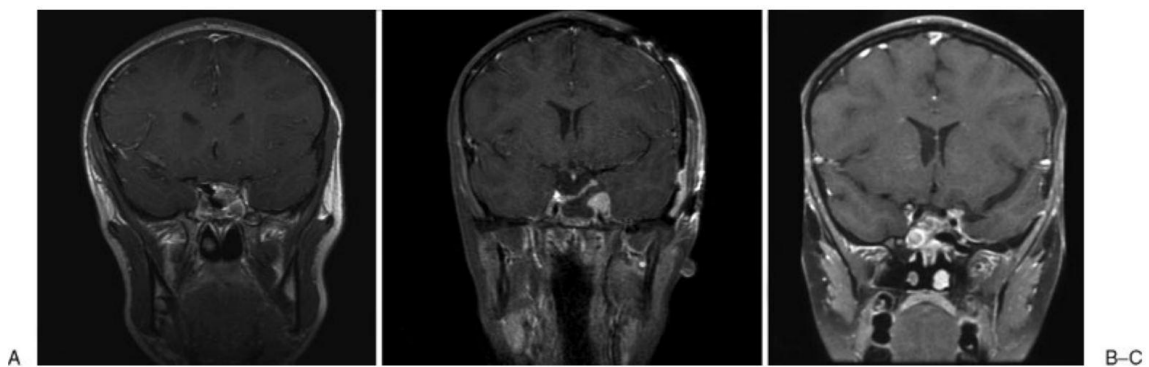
T1-weighted contrast enhanced follow-up imaging.
